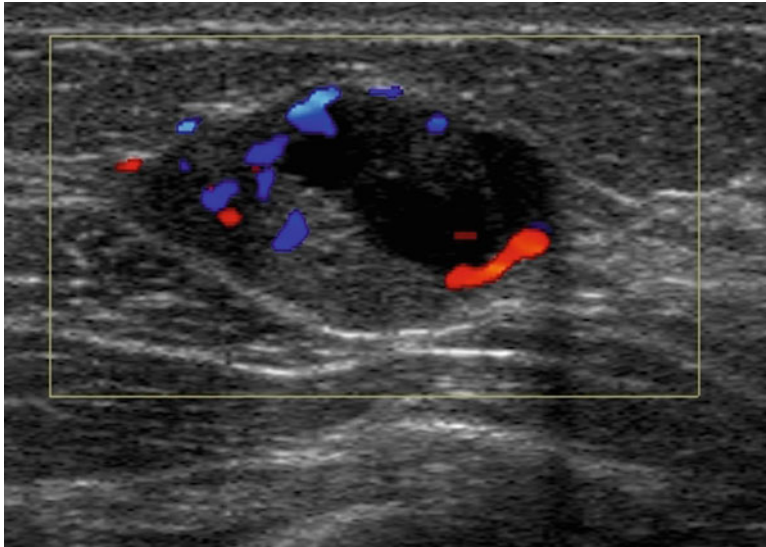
Palpable right breast mass showing indeterminate sonographic features. US-guided core biopsy confirmed a fibroadenoma
